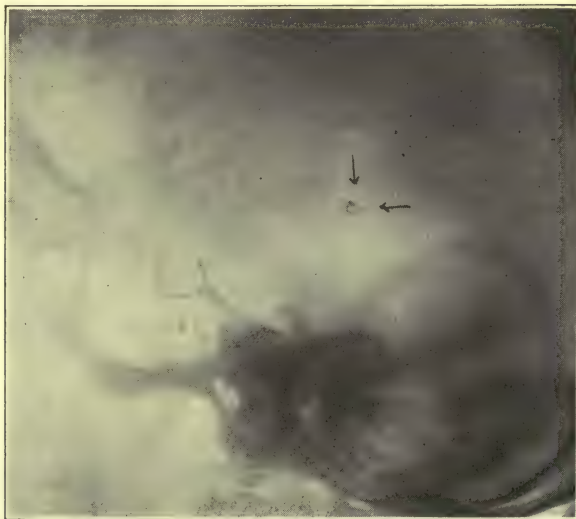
Showing pineal shadow in the roentgenogram of the patient, Fig. 13 and 14.
